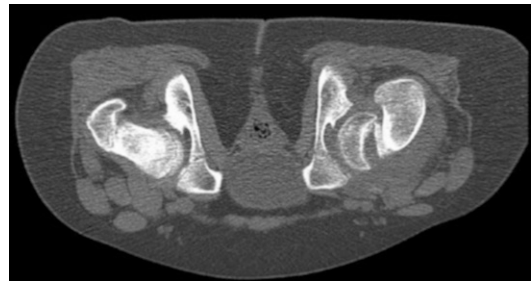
If in a slipped capital femoral epiphysis the epiphysis has slipped far, then flexion and abduction of the involved hip are extremely limited and it is not possible to take a lateral X-ray of the hip to get a reliable impression of the degree of slippage; a CT-scan would be the best method. The capital femoral head epiphysis of the left hip shows severe slippage
